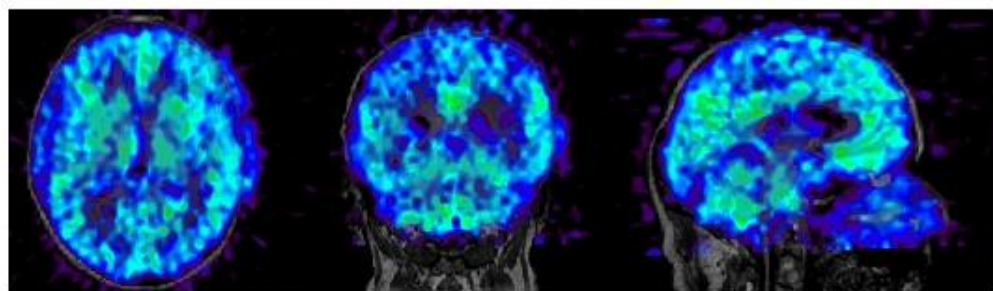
Rotated Coloured PET Water Dynamic Image Co-Registered with MRI Scan.
